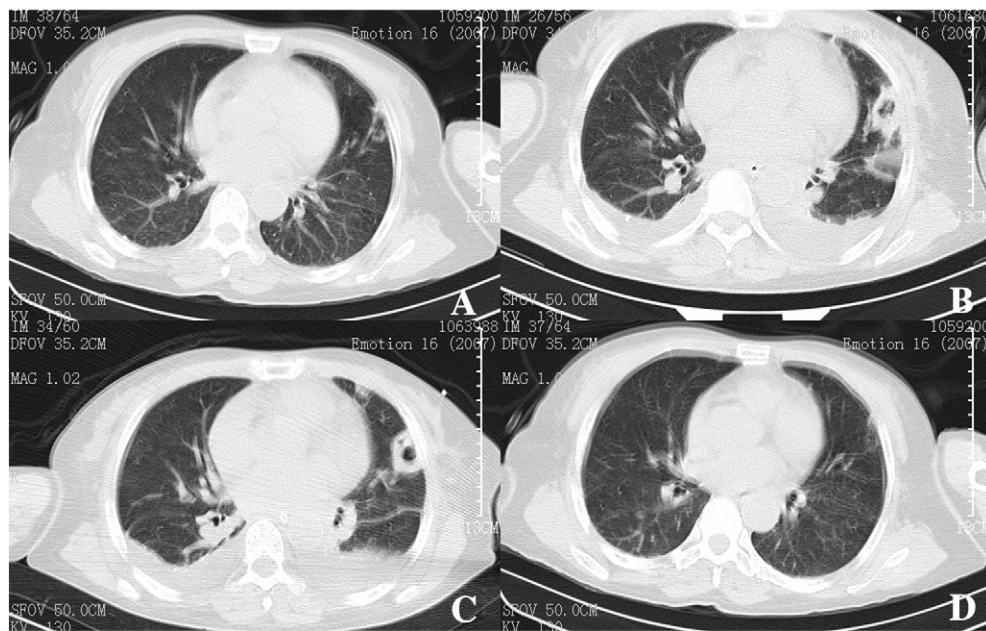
Serial changes of chest computed tomography (CT) during clinical course. A, CT scan was obtained on ward floor, showing patchy inflammatory lesions in the left lung. B, CT scan obtained on the third ICU day, showing lesion of cavity on the left lung. C, CT scan obtained on the sixth ICU day, showing that the lesion remained unchanged. D, CT scan obtained 2 months after ICU admission during follow up, showing that the lesion was recovered.
